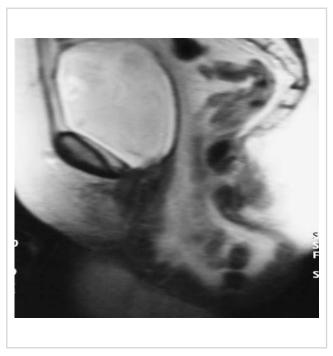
Magnetic resonance image demonstrating a well-supported bladder (white on T2-weighted study), but significant enterocele behind it.
